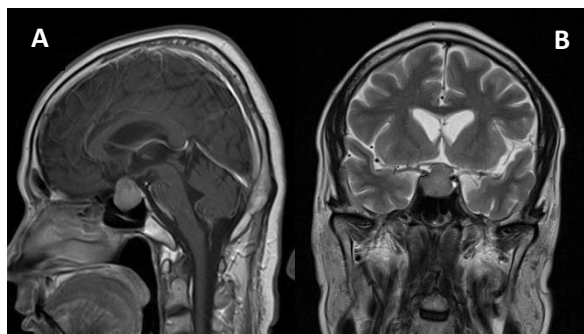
Magnetic resonance imaging sagittal (A) and coronal (B) sections of the brain showing a sellar mass measuring 18.6 mm x 17.9 mm x 20.2 mm resulting expansion of the pituitary fossa suggestive of pituitary macroadenoma.
